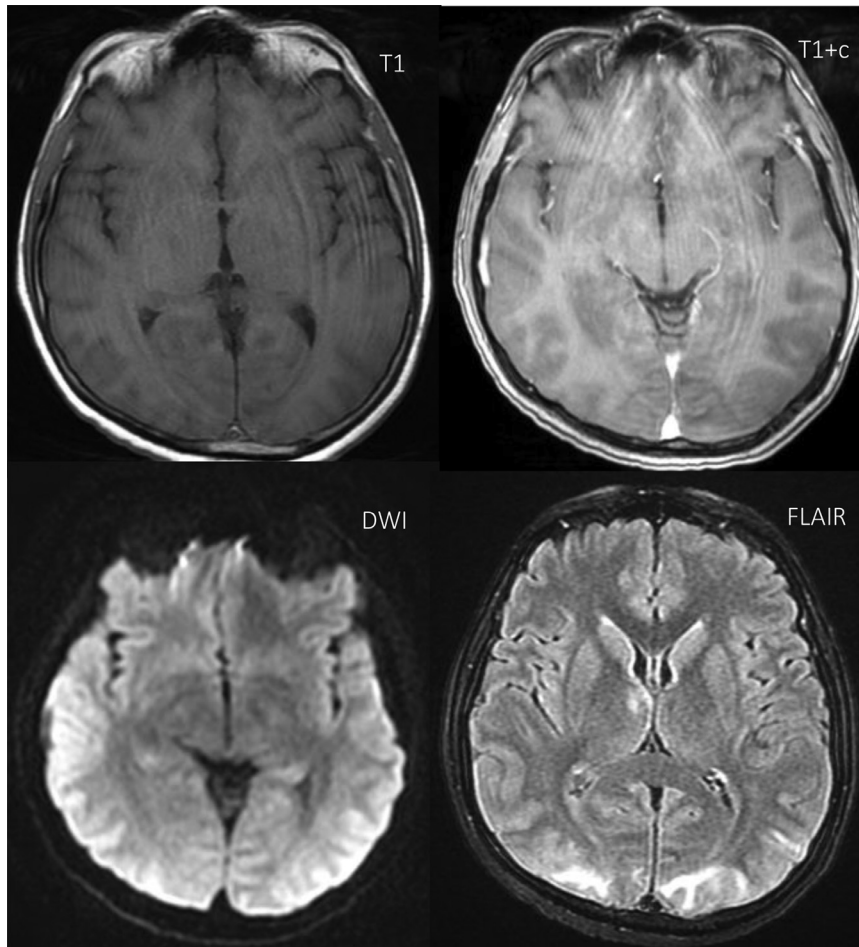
Axial magnetic resonance image demonstrating small hyperintensity seen at right thalamic without notable restriction and diffusion seen nor enhancement. No identified meningeal enhancement seen.
